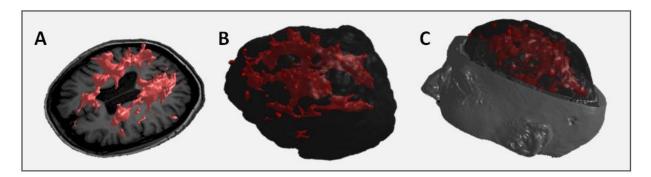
Three-dimensional (3D) rendering of segmented MS lesions derived from high-resolution MRI scans and displayed on A) axial image, B) skull stripped brain-rendered image, and C) whole head-rendered image.
